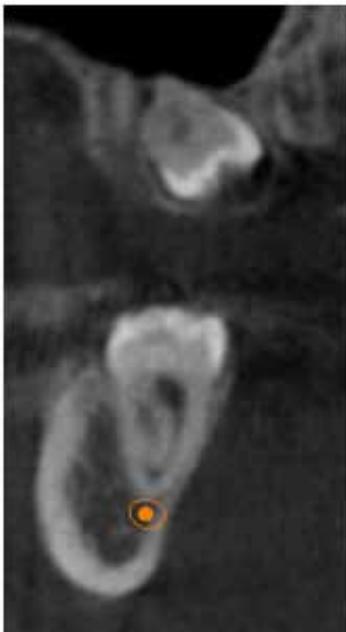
Coronal CBCT slice interpretations of the distance between root apex and IAC.
